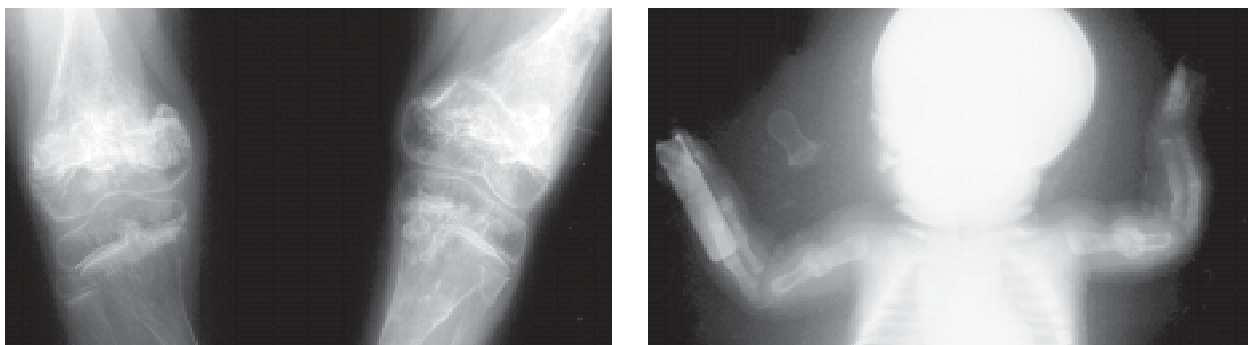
Anteroposterior X-ray of both knees of a 6-year-old girl with type III osteogenesis imperfecta. Typical "popcorn" calcifications in the region of epiphysis and metaphysis.
